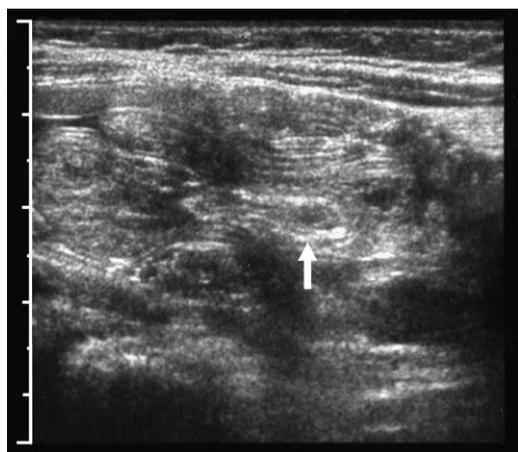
Long-axis sonographic view shows an elongated appearance resulting in a pseudokidney appearance (arrow).
